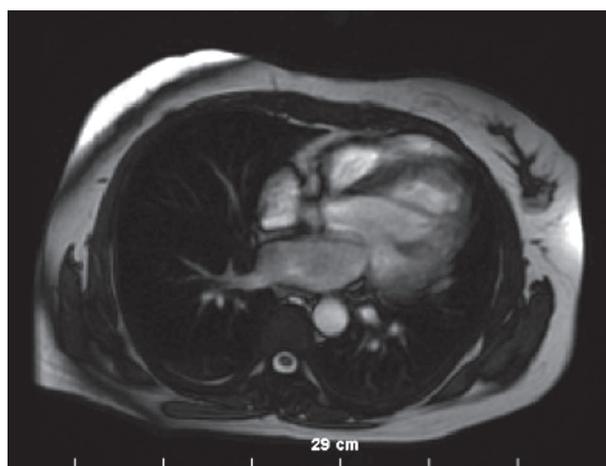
Patient's MRI findings
